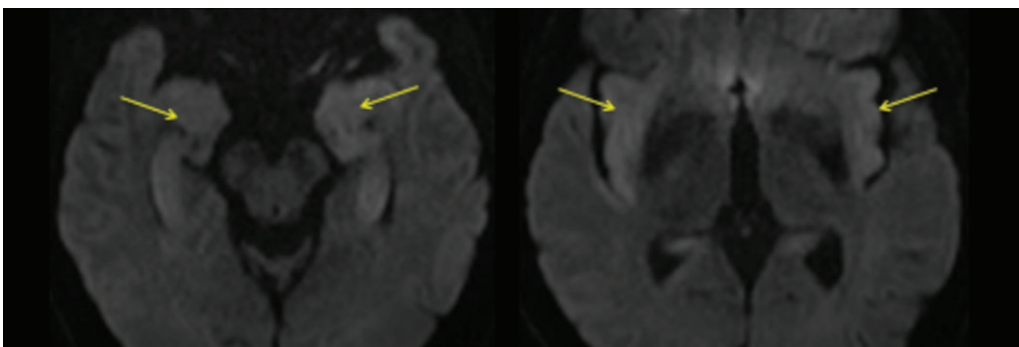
Increased DWI signal (B 1000) of mesial temporal lobes and insulae (yellow arrows).
